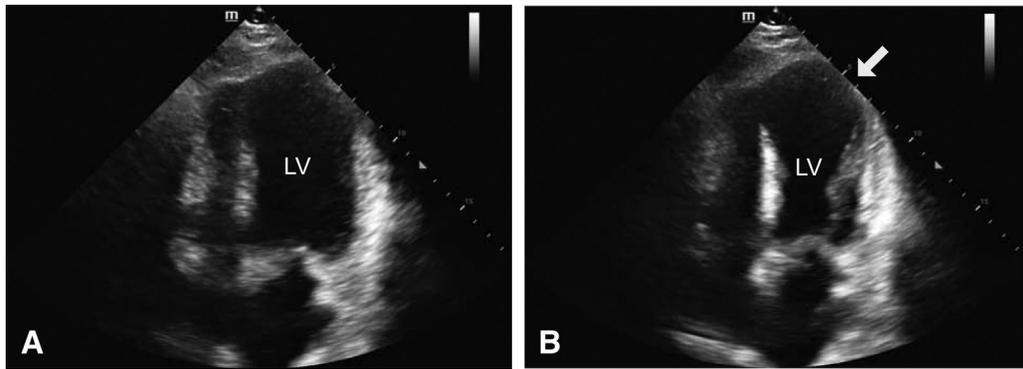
Bedside point-of-care cardiac ultrasound in apical four chamber view showing aneurysm (arrow) of the distal septum and inferior left ventricle (LV). Apical four view of the heart during ventricular diastole (A) and ventricular systole (B).
